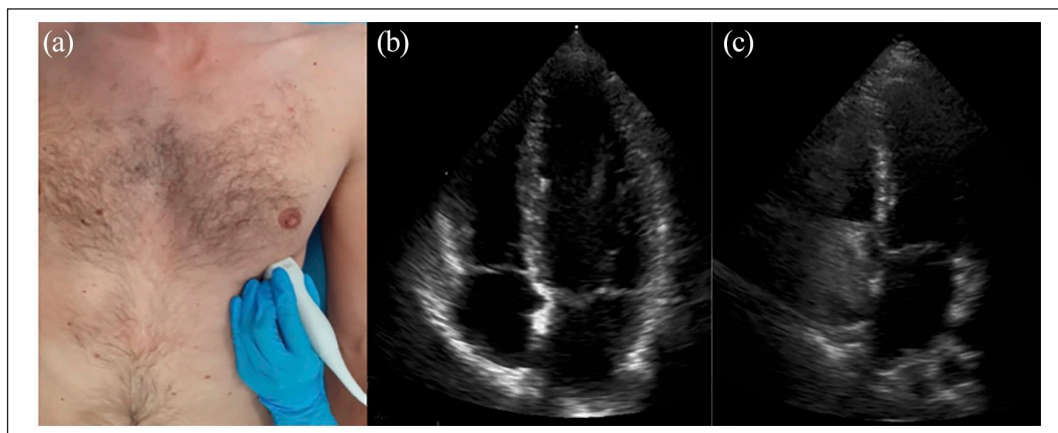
Transthoracic apical four-chamber view: placement of the probe (a), visualization of the heart chambers (b), and visualization of the microbubbles in the right atrium (c).
